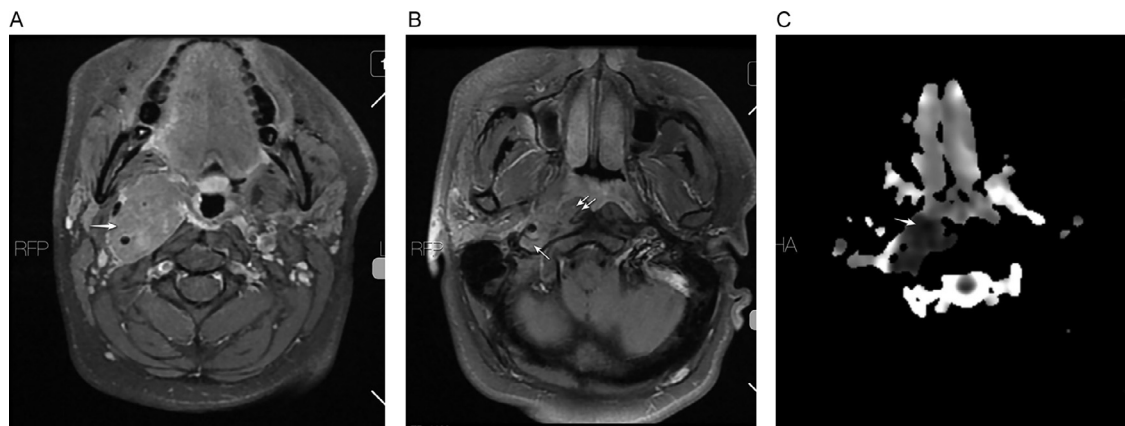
MRI findings. (A) An infiltrative mass is identified within the right carotid sheath, infiltrating into the superior retropharynx and nasopharynx, (B) Superior extension is visible to the level of the jugular foramen. Involvement of the longus capitis muscle at same level depicted (C) Significantly restricted diffusion is evident in axial ADC map.
